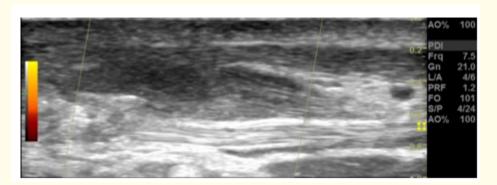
Absence of color acquisition by color echo-doppler
